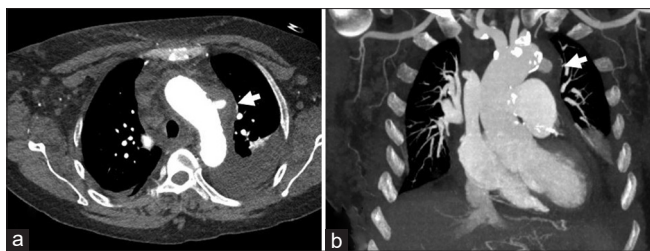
Axial (a) and coronal (b) images from the computed tomography angiography of the chest reveal a 1-cm saccular aneurysm of the aortic arch surrounded by a thick rim of inflammatory tissue (arrows)
